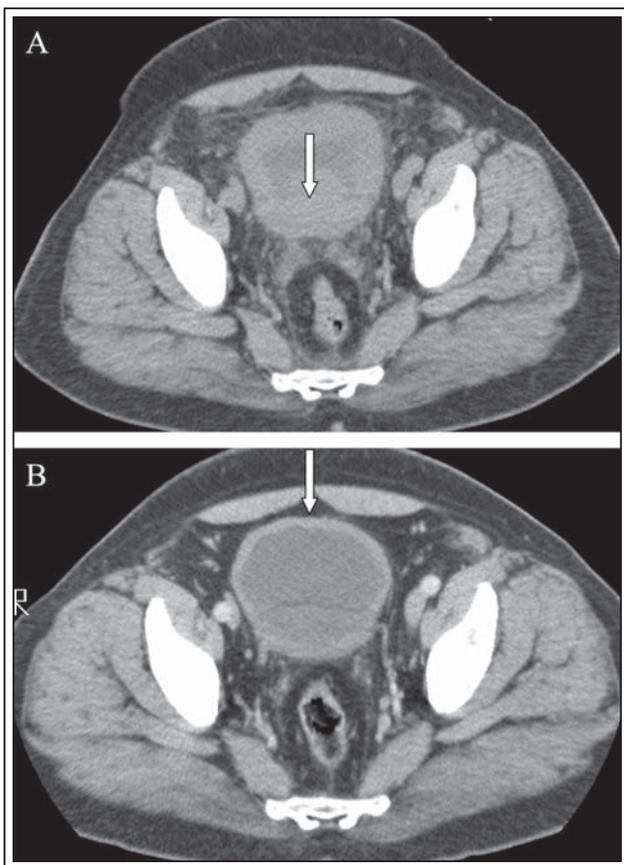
Helical CT scans showing bladder wall thickness before (panel A) and 3 months following TURP (panel B).
